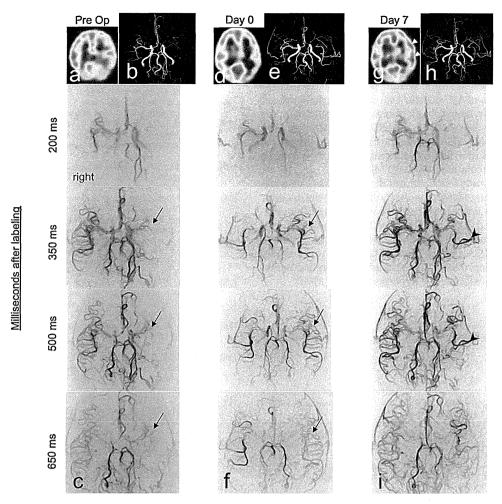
Representative images of SPECT (a, d, g), conventional TOF MRA (b, e, h) and ASL-4D MRA (c, f, i) in a patient with focal hyperperfusion after combined revascularization for the left hemisphere (Case 3). Preoperative SPECT shows decreased CBF in the left hemisphere (a). Serial images of preoperative ASL-4D MRA (c) shows a relatively weak and delayed signal for the MCA in the left hemisphere (arrow; c) compared with the opposite hemisphere. SPECT, TOF MRA, and ASL-4D MRA immediately after surgery (Day 0; d-f) shows improvement in CBF and visualization of the left MCA branches (arrow; f). At postoperative Day 7, SPECT detects focal hyperperfusion in the left frontotemporal cortex around the bypassed site (white arrowheads; g). ASL-4D MRA shows focal hyperintense signals on the bypassed arteries (arrow heads; i) at phases of 350 and 500 ms. The detection site and days after surgery for these findings by ASL-4D MRA are consistent with those for focal hyperperfusion shown by SPECT. There is no change in TOF MRA between postoperative Day 0 (e) and Day 7 (h).
